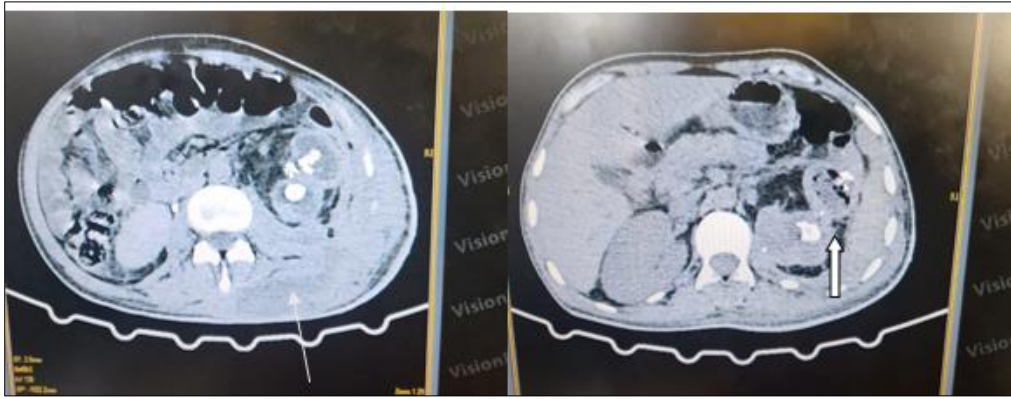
Abdomino-pelvic CT scan revealing obstructive left pyelonephritis complicated by a psoas abscess and uro-digestive fistula
